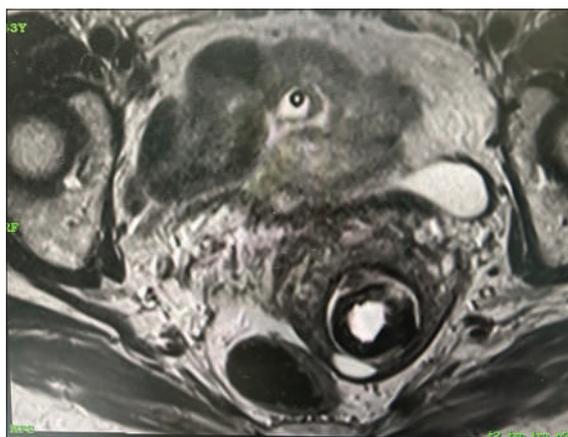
Magnetic resonance imaging showing cervical ectopic pregnancy
